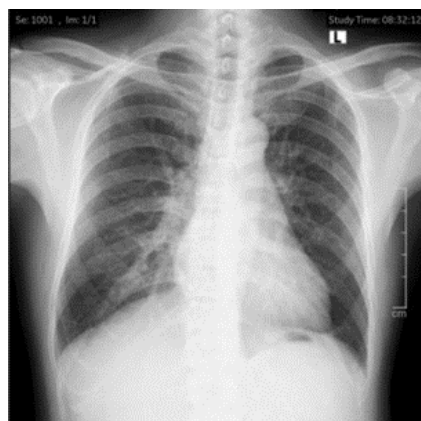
Chest X-ray before administering TKI therapy.
